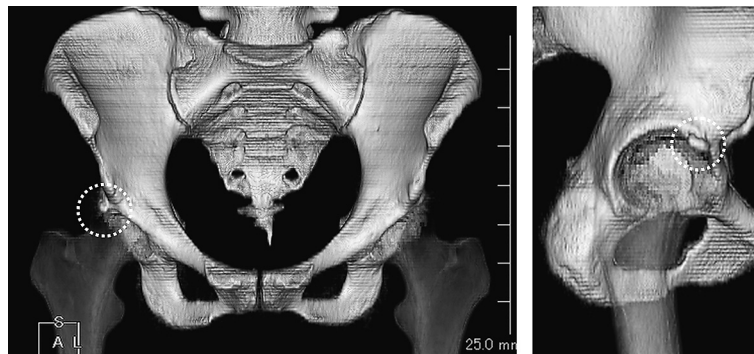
Three dimensional reconstruction computed tomography of the pelvis.
